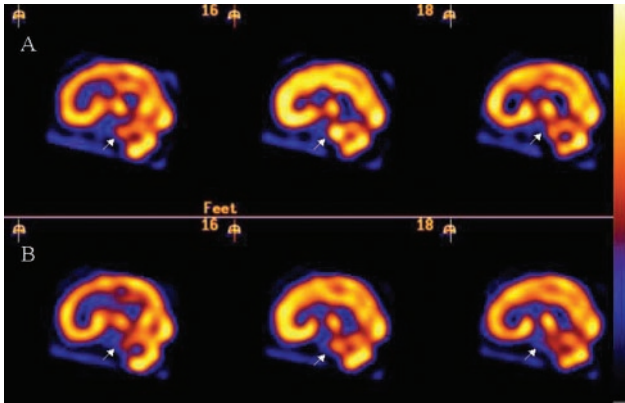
A 6-mm-thick sagittal plane reconstructed ^{99m}Tc SPECT imaging of a 44-year-old female with SAH after rupture of an anterior communicating artery aneurysm. White arrows point to the BS. A, Baseline BS perfusion is normal, as can be seen by the intense and bright uptake signal in the pons area (arrows), which is equal in intensity compared with the rest of the brain territories. B, On day 7 after the initial hemorrhage, the patient presented with RLC and elevated BA TCD-MFVs (110 cm/s). SPECT imaging disclosed moderate reduction in BS rCBF, (shown as decreased uptake intensity signal, arrows) compared with baseline imaging (A) and other brain territories.
